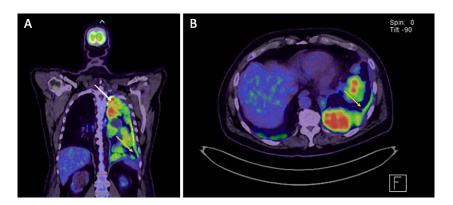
¹⁸FDG whole body PET scan performed revealed extensive uptake throughout the left hemithorax in multiple pleural masses extending from the apex (white arrow) to the inferior costophrenic recess (yellow arrow). (A) Coronal view. (B) Axial view.
